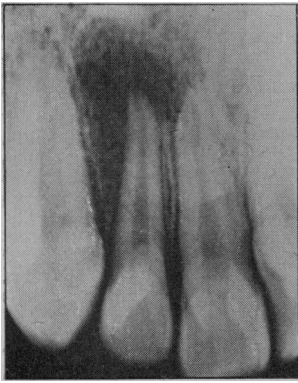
(Case II).—Radiographic appearance of the right lateral incisor in a patient presenting with the symptoms of an acute apical abscess.
